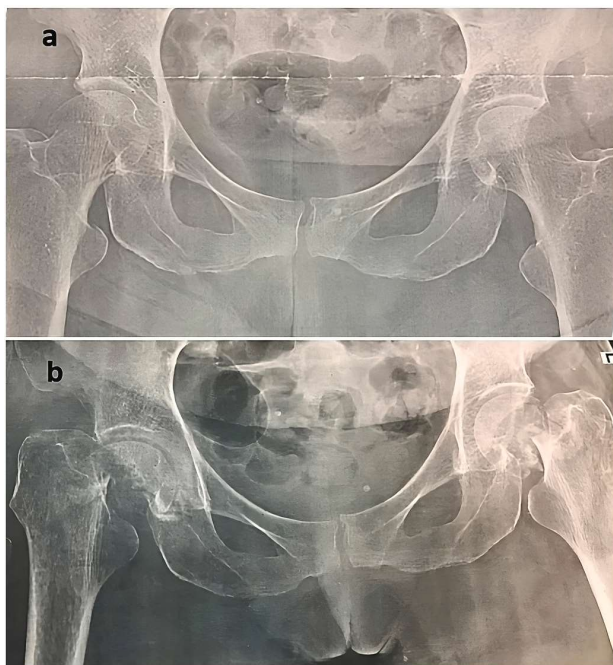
(a) Radiograph taken on the same day of the accident, 40 days before the admission (b) Radiograph taken on the day of the admission, 40 days after the accident.
